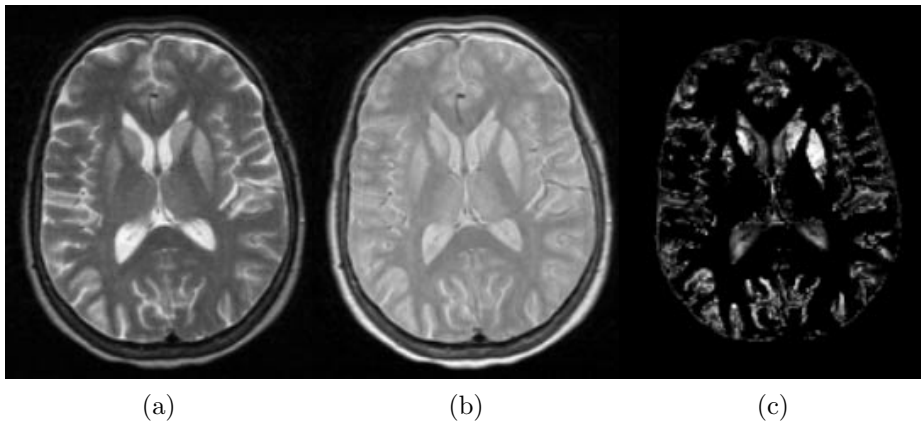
Outlier detection on a brain MR scan of a patient suffering from sporadic CJD. T2-weighted image (a); PD-weighted image (b); outlier belief values (c).
